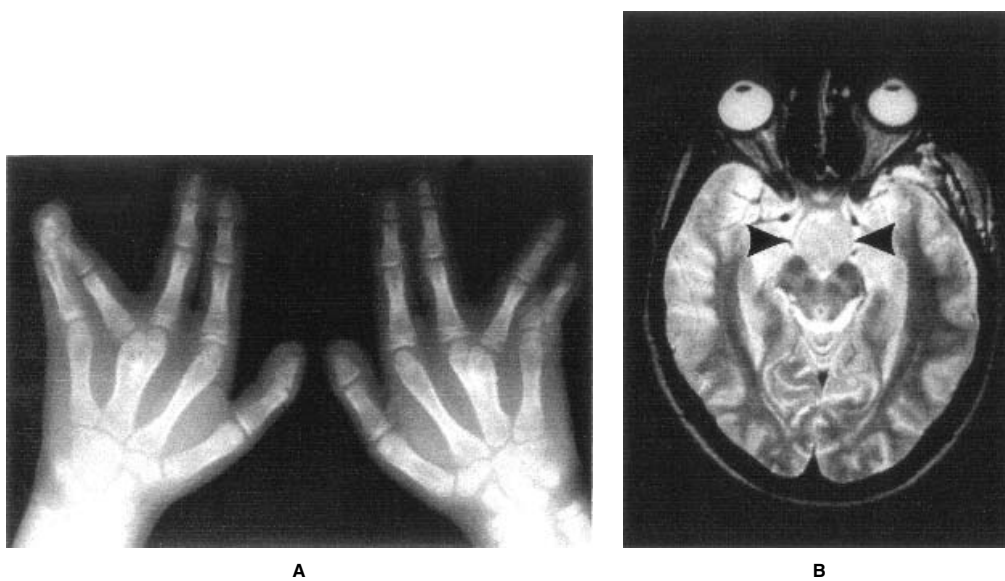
Pallister-Hall syndrome. (A) Syndactyly of metacarpals III/IV, surgically corrected postaxial polydactyly. (B) Hypothalamic hamartoma (MRI scan, black arrow heads). (With permission from M. Löw et al. [208].)
